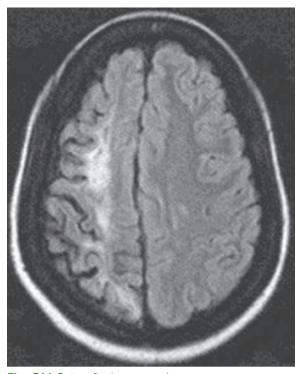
Fast fluid-attenuated inversion recovery sequence MRI of the brain showing a right hemisphere border-zone cerebral infarction in a child with sickle cell anemia. (From Switzer JA, Hess DC, Nichols F, et al. Pathophysiology and treatment of stroke in sickle-cell disease: present and future. Lancet Neurol 2006;5:501-512.)
